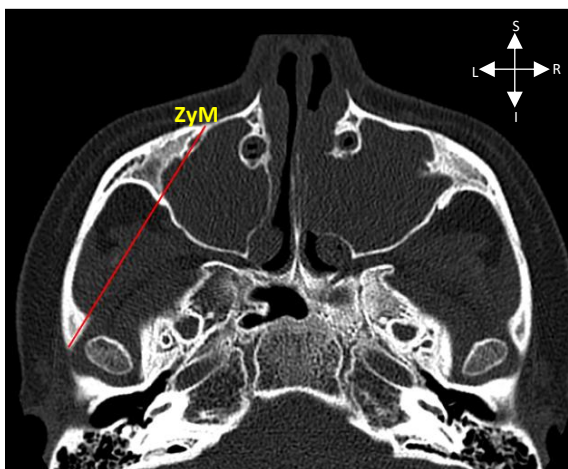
Horizontal CT scan in the midfacial region displaying the Zygomatic arch length (red) (superior view)
